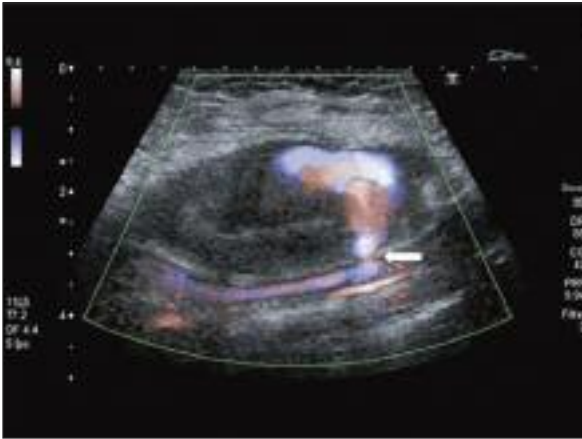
Color doppler sonogram shows typical Swirling pattern of flow within pseudoaneurysm (54.8 x 24.7 mm in diameter). Arrow indicates the neck of pseudoaneurysm.
